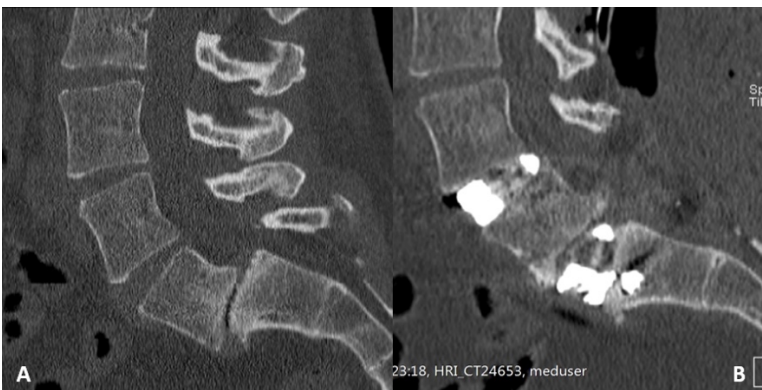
A. Pre and B. post-operative CT-Scan of a L4-L5-S1 ALIF for treatment of 2°
